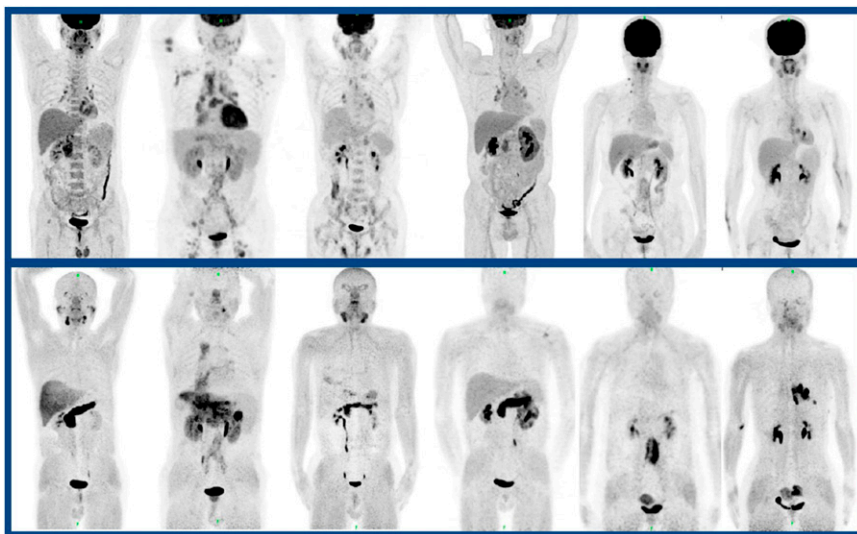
^{68}Ga -FAPI PET/CT imaging of fibrosis in IgG4-related disease. Top row: ^{18}F -FDG PET/CT imaging in a series of 5 patients with IgG4-related disease. Bottom row: Corresponding ^{68}Ga -FAPI PET/CT images acquired in the same patients. ^{68}Ga -FAPI PET/CT showed a larger number of organs involved in about half of patients, with the most involvement identified in the pancreas, salivary glands, bile duct/liver, and lacrimal glands. ^{18}F -FDG uptake was higher in the lymph nodes, but this is associated with less morbidity. This work highlighted the ways in which different tracers can show varying aspects of disease, in this case organ vs. nodal involvement.
